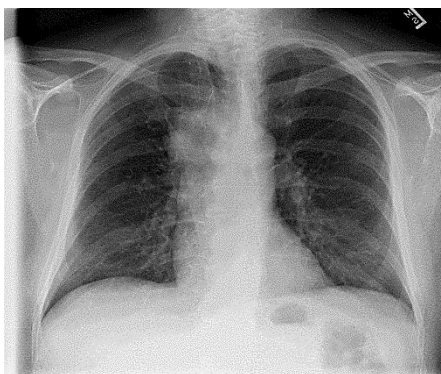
Effusion Chest X-ray
